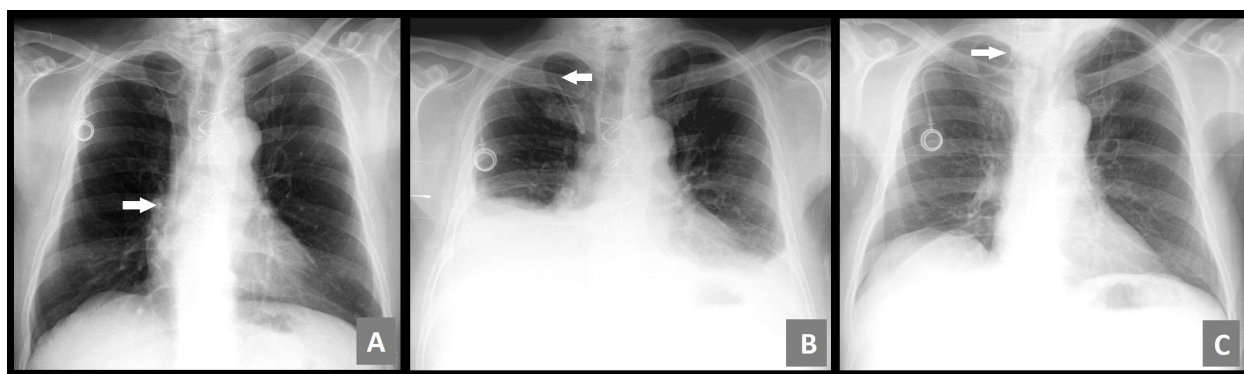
Chest X-ray: A (September 2015) – confirming the correct position, after TIVAD was introduced; B (August 2016) – during emergency room, due to cough, nausea and vomiting; C (April 2017) – after patient presented symptoms during a chemotherapy session; → : catheter tip position.
